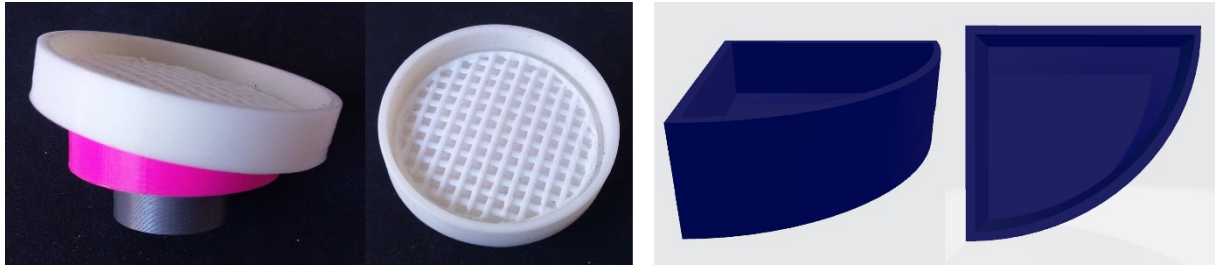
Sample holder for  $\mu$ CT measurements of intravesical inserts for unfolded (images, left) and folded (CAD models, right) inserts.
